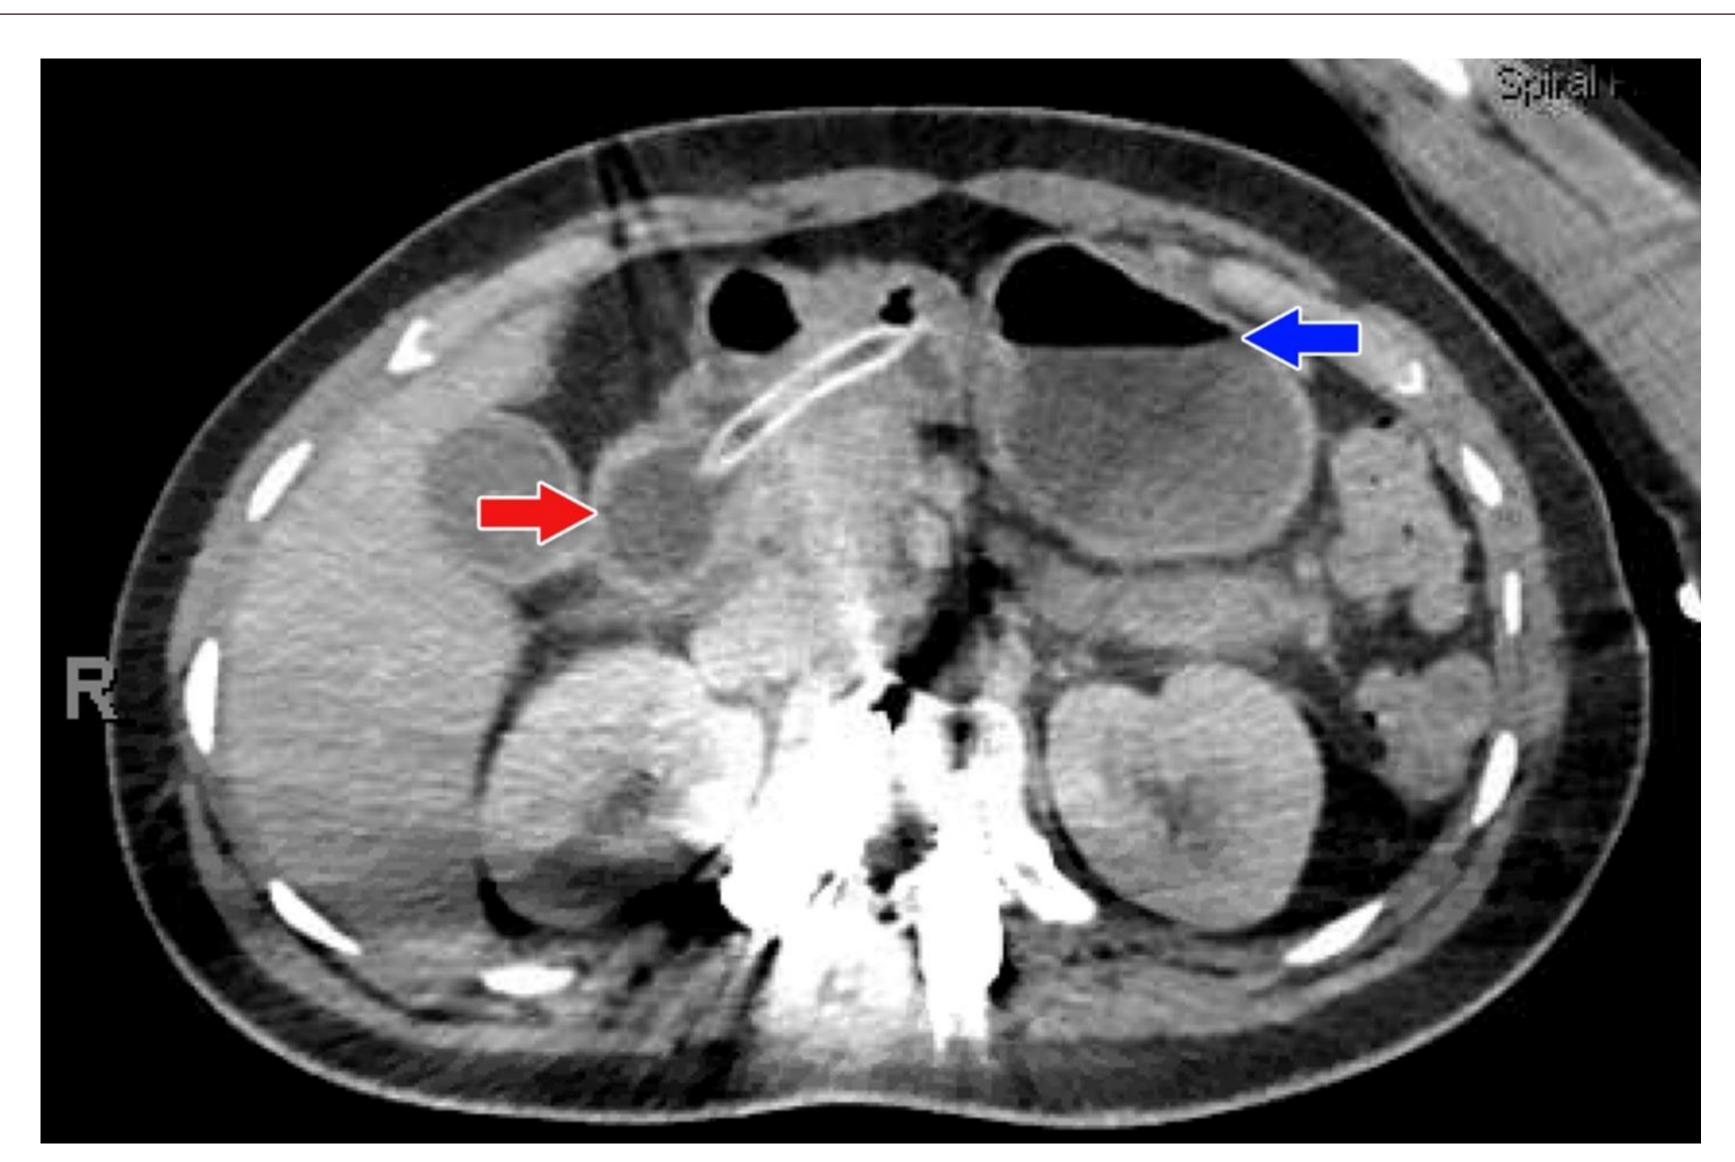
CT abdomen showing percutaneous feeding tube with balloon inflated in the second portion of the duodenum (red arrow) and mild fluid level within the stomach (blue arrow).
